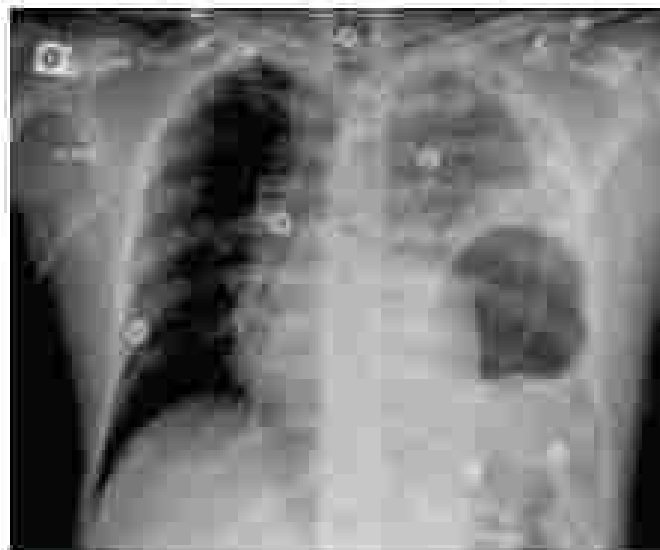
Chest radiograph depicting typical findings of an acute traumatic diaphragmatic injury with a hemothorax containing normal fluid on the left hemithorax, multiple rib fractures on the left side, and a curved nasogastric tube in the left side of the chest. (From *Textbook of Thoracic Trauma*, 2nd edn, © 2012 by Elsevier, p. 1058.)
